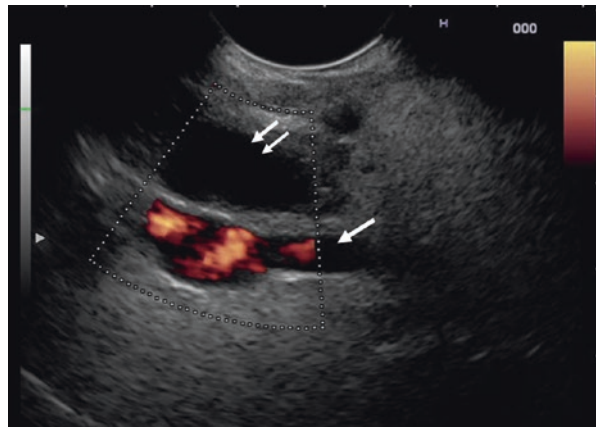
Color Doppler ultrasound may be used to identify flow in blood vessels (arrow) while cystic lesions appear as anechoic areas (double arrow)
